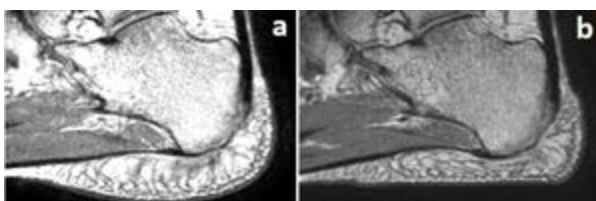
(a) MR image of the heel at rest. (b) MR image of the loaded heel.
